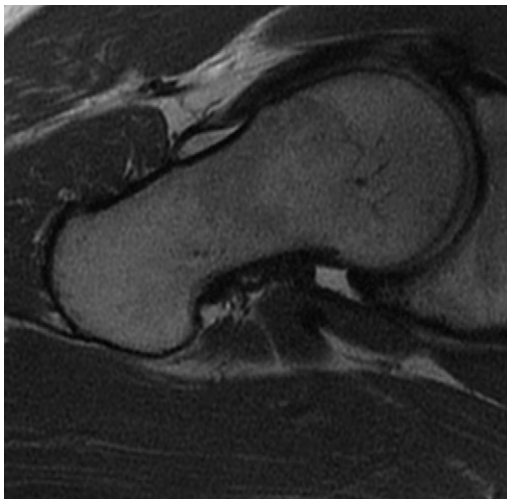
A nonspherical femoral head as seen on MRI.
